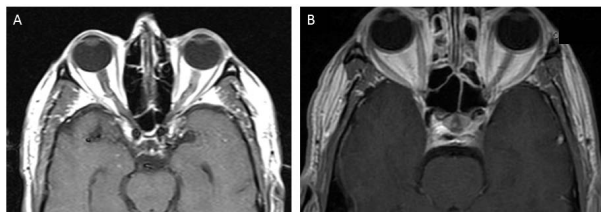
MRI brain of patient and control. (A) T1 axial post-gadolinium MR image of our patient at presentation showing uniformly atrophic extra-ocular muscles; (B) T1 axial post-gadolinium MR image of a healthy age-matched control patient to serve as a comparison for extra-ocular muscle size.
